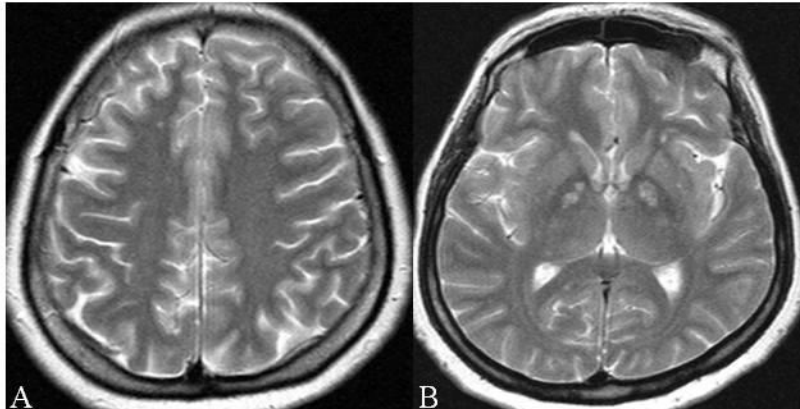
T2-weighted axial image shows milimetric sized hyperintense lesions on the white matter.
